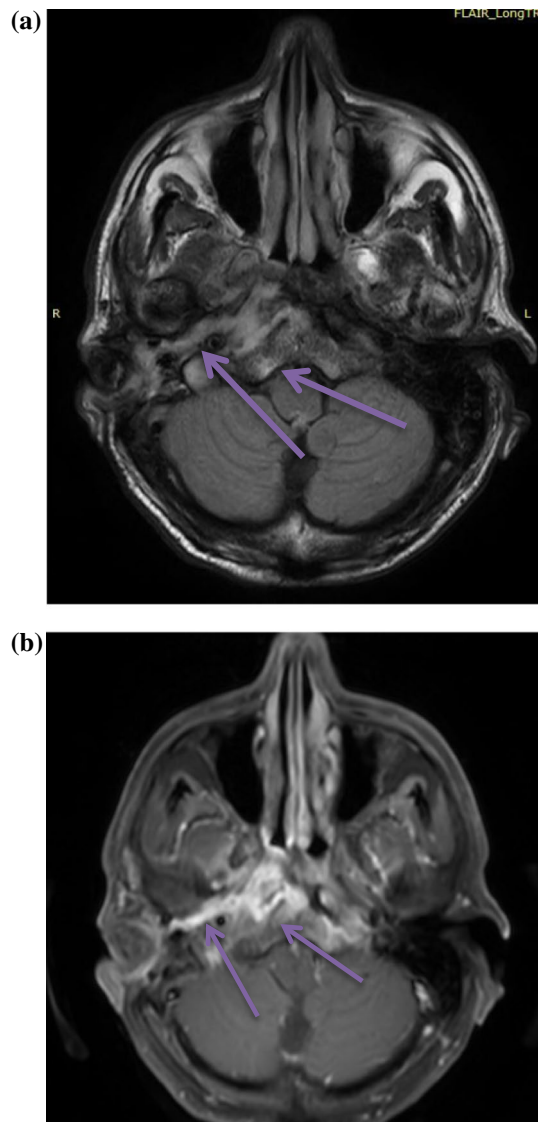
a A 66-year-old male (→ showing the following imaging features) right malignant otitis externa with oto-mastoiditis and skull base osteomyelitis. Shows FLAIR hyperintensity in right middle ear cavity, right mastoid, right petrous apex, clivus, left occipital condyle right torus tubaris, right pterygoid space, nasopharynx, longus colli muscle and visualised right parapharyngeal and prevertebral spaces. b A 66-year-old male (→ showing the following imaging features) right malignant otitis externa with oto-mastoiditis and skull base osteomyelitis. Shows significant post contrast enhancement in right middle ear cavity, right mastoid, right petrous apex and clivus. Mild enhancement of right fronto-parieto-occipital pachy meninges
